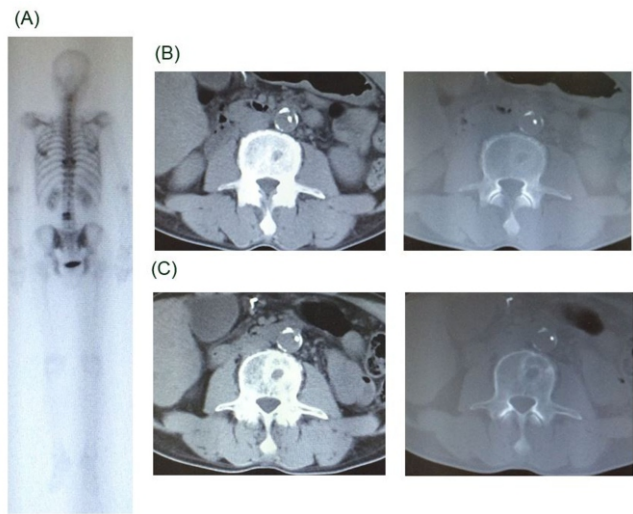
The CT and $^{99\text{m}}\text{Tc}$ HMDP bone scintigraphy of a 63 years old man with bone metastases from HCC. Technetium-99m HMDP accumulated in ninth thoracic vertebrae and fourth lumbar vertebrae, which were metastatic bone tumors (A). He underwent concurrent therapy of $^{89}\text{SrCl}_2$ (116MBq) and Zoledronic acid (ZA) of 4mg/body. The CT before the therapy shows osteolytic lesions due to metastases (B). The CT after the concurrent therapy shows an increase of bone metastatic lesions (C). The Numeric Rating Scale (NRS) score increased from 7 to 8. External radiotherapy (30Gy) was added, and the NRS score decreased to 7. The tumoricidal effect was assessed to be progressive disease (PD).
